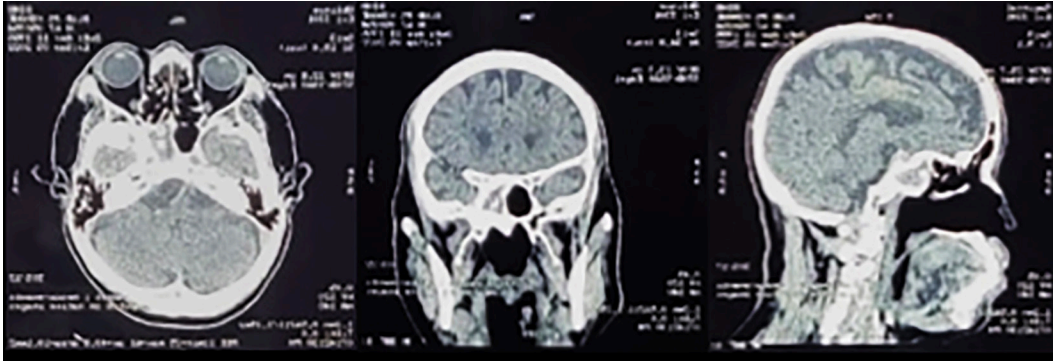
Non-contrast CT scan of the head. A solid lesion with calcification within the sphenoid and temporal sinus region of sinistra.
